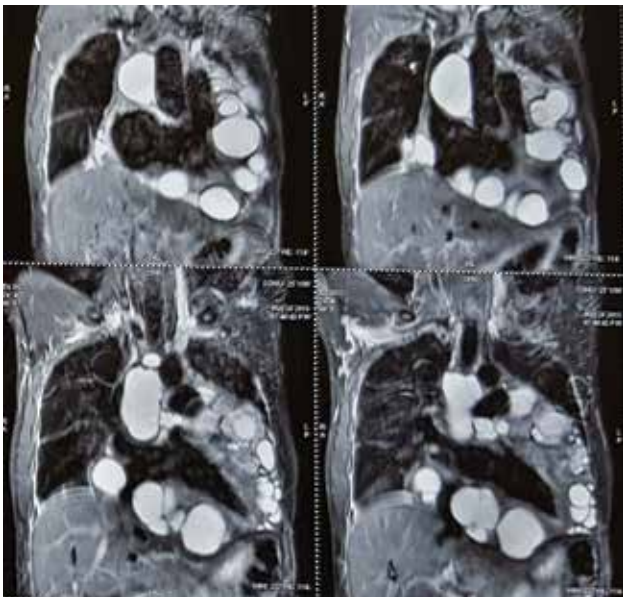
Magnetic resonance imaging of chest showing multiple cystic lesions in peri-cardiac, pre-carinal, sub-carinal and pre-vascular areas indenting the adjacent lung parenchyma and cardiac chambers.
